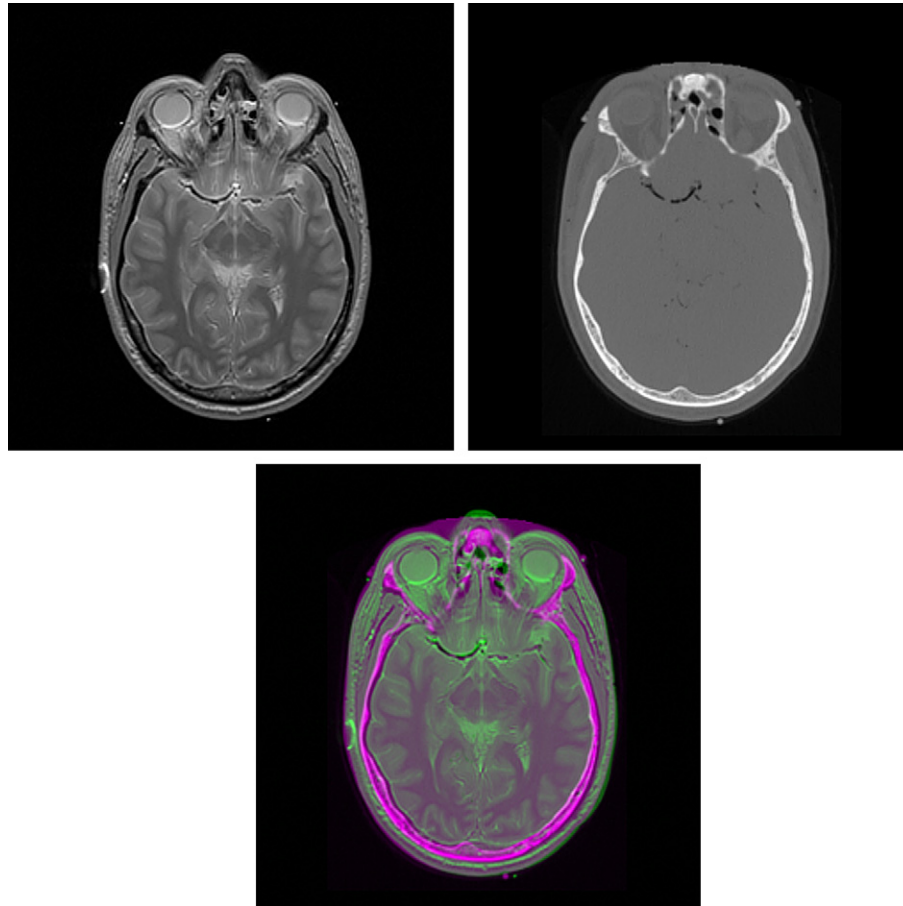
An axial cranial slice: (a) Top-left image: PD-weighted MRI scan, (b) Top-right image: CT scan, and (c) Bottom image: fused image.
